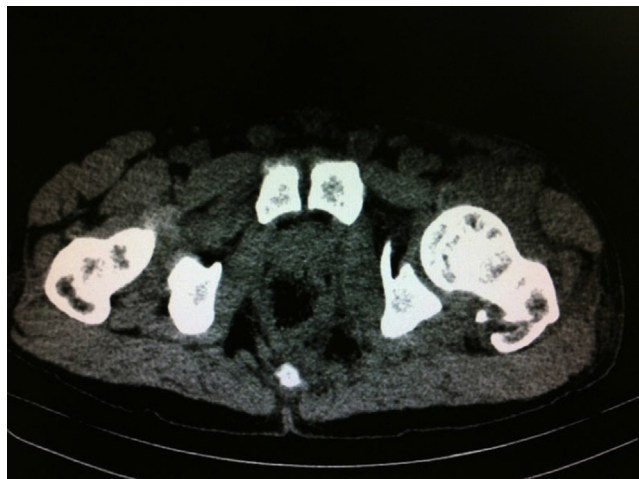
Postreduction CT showing fracture of left greater trochanter.
